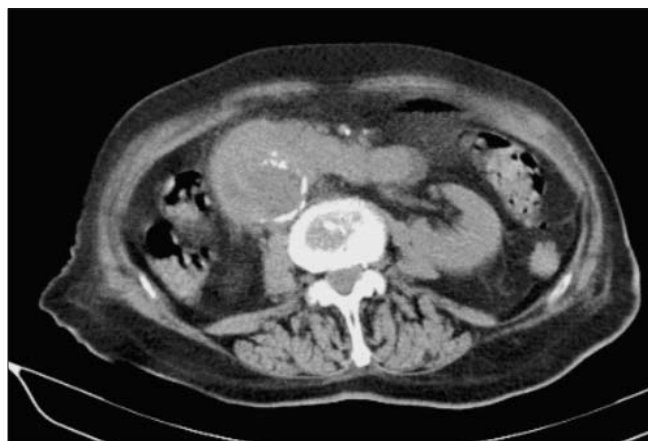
Non-enhanced computed tomography: discontinuity of the aortic calcified atheroma on the right convexity of the aneurysm that suggests rupture
